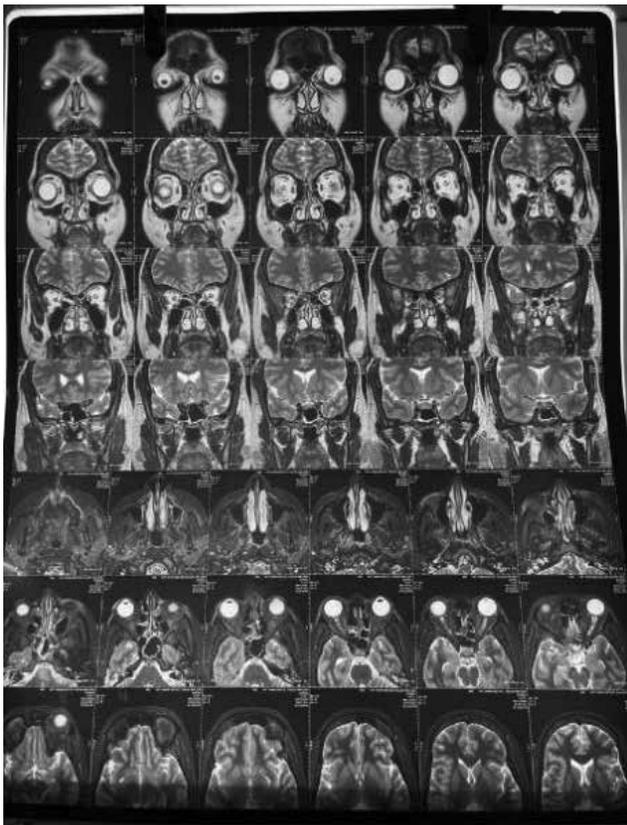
MRI brain showing left optic.
